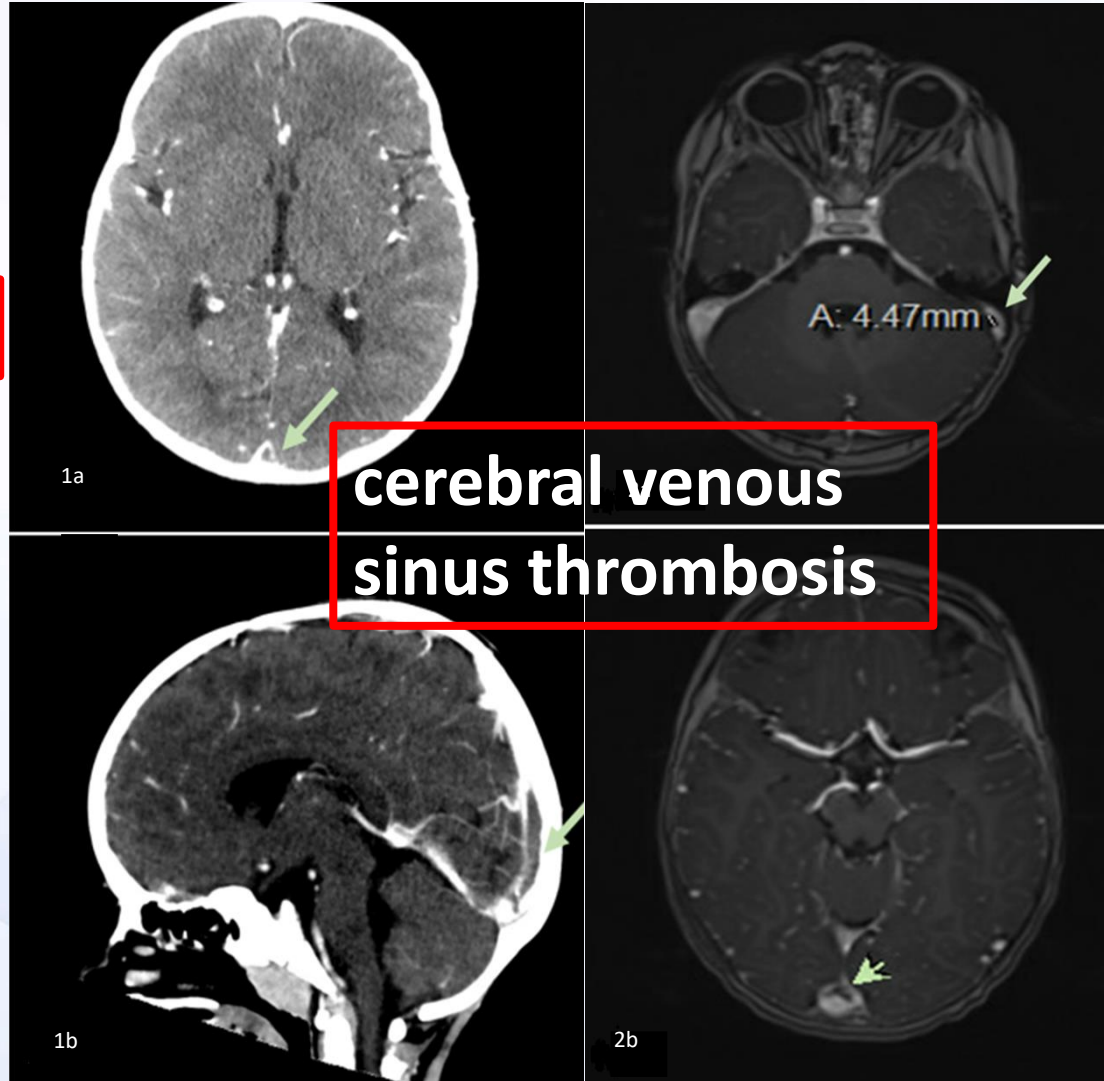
CT scan of the brain without and with IV contrast
